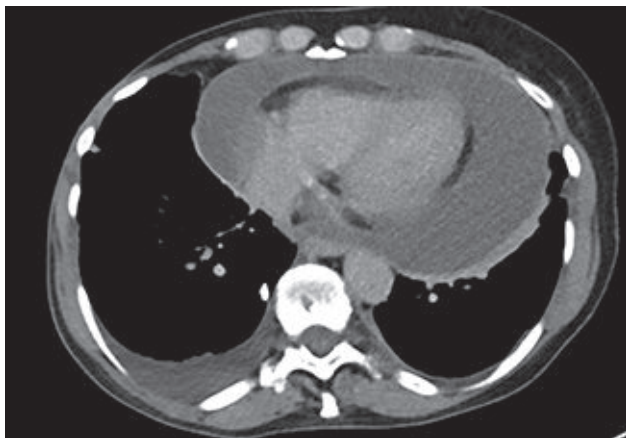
CT abdomen showing large circumferential pericardial effusion with fluid at the apex measuring 3.5cm
